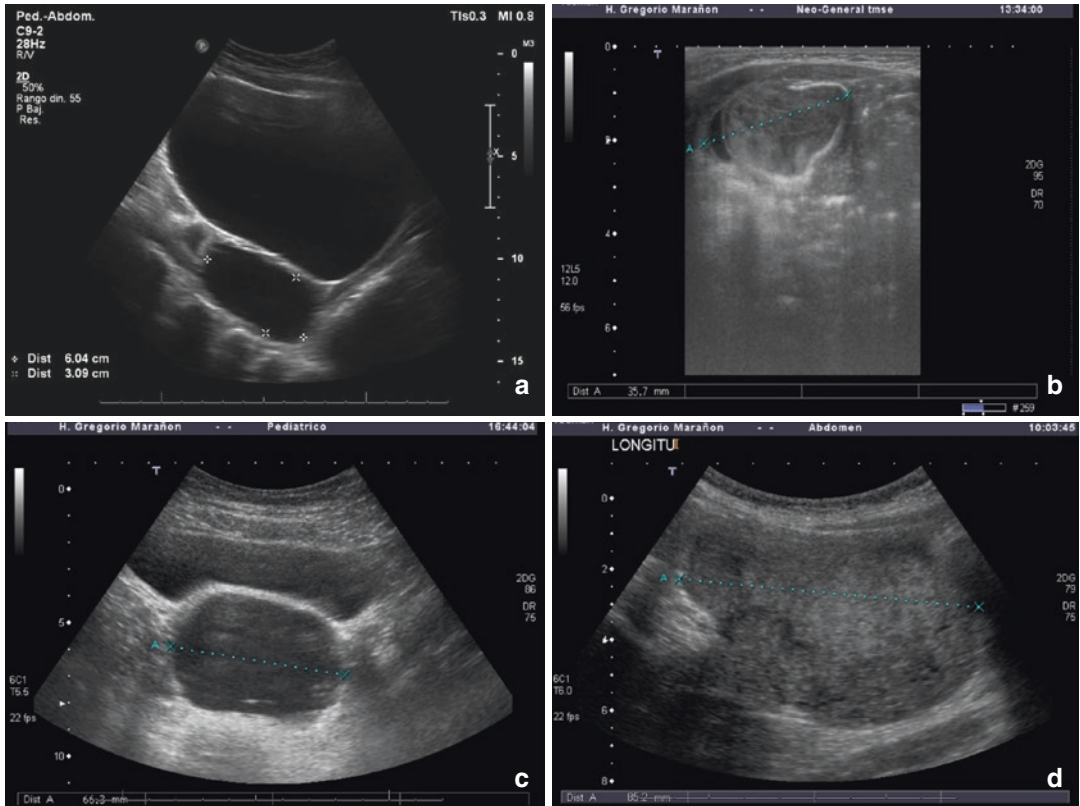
Ultrasonographic images of ovarian cystic and solid lesions. (a) Simple cyst. (b) Complicated cyst. (c) Cystic teratoma. (d) Solid tumor
